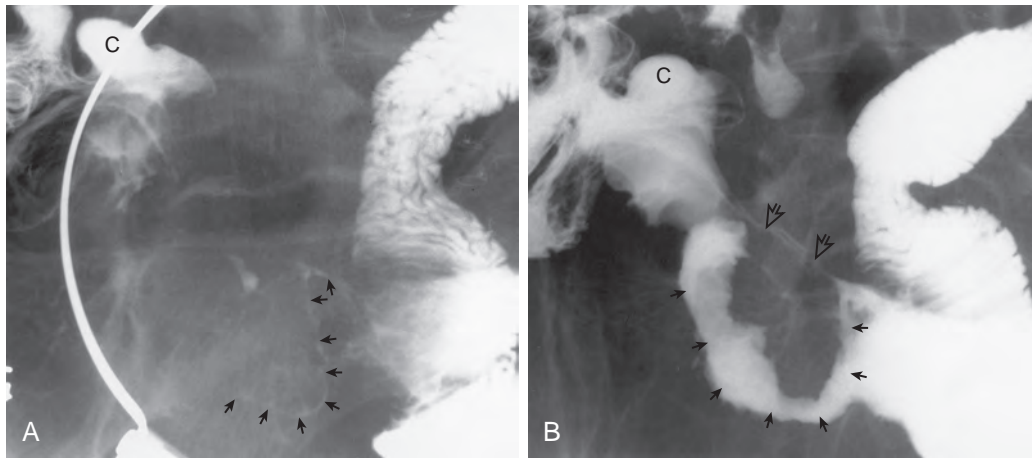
Value of metoclopramide for evaluating narrowing of the terminal ileum in a patient with Crohn's disease. A. Spot radiograph from a small bowel follow-through shows a stringlike segment of narrowing (arrows) in the terminal ileum inferior to the cecum (C). B. After metoclopramide has been administered, the narrowed segment (short arrows) distends considerably but is still abnormal, with effaced folds and nodular mucosa caused by Crohn's disease. An ileoileal fistula (open arrows) is also visualized. These images show how narrowing in Crohn's disease may be caused by a combination of spasm, edema, inflammatory change, and fibrosis.
